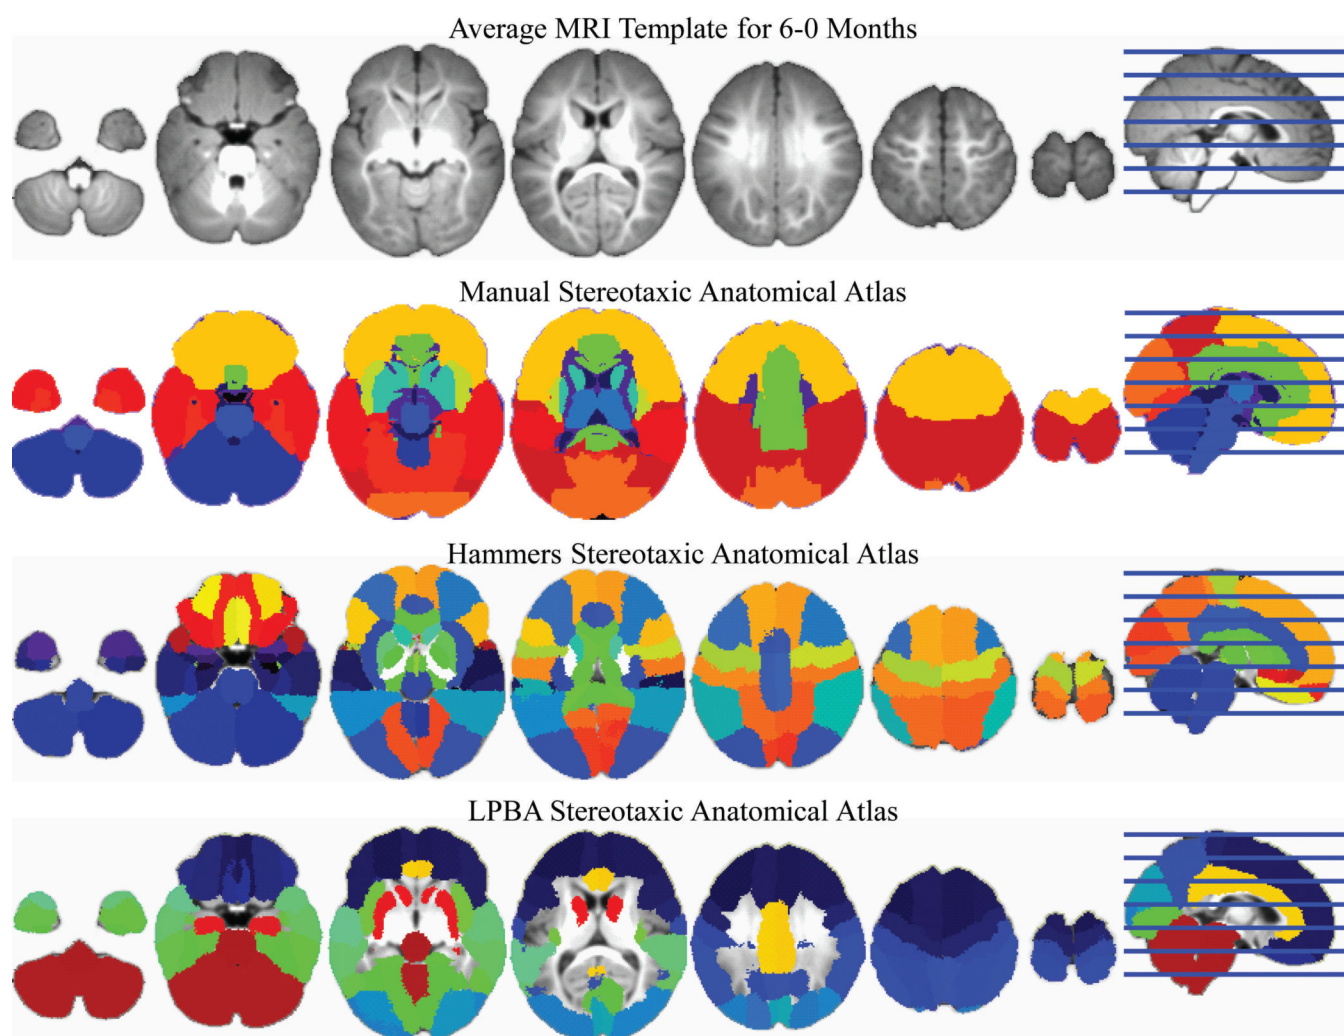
Slices of average MRI template for 6-0 months participant, compared with manual, Hammers, and LPBA40 atlases.
